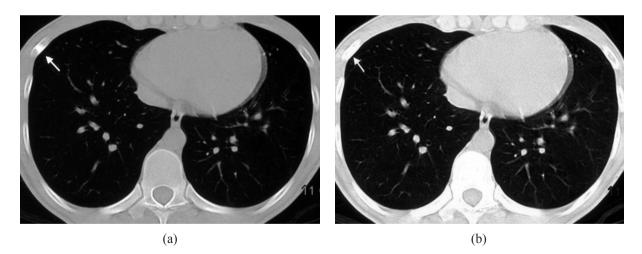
Computed tomography (CT) scan of the chest showing a hyperdense lesion at the right 6th rib in the bone window (a) and in the lung window (b).
